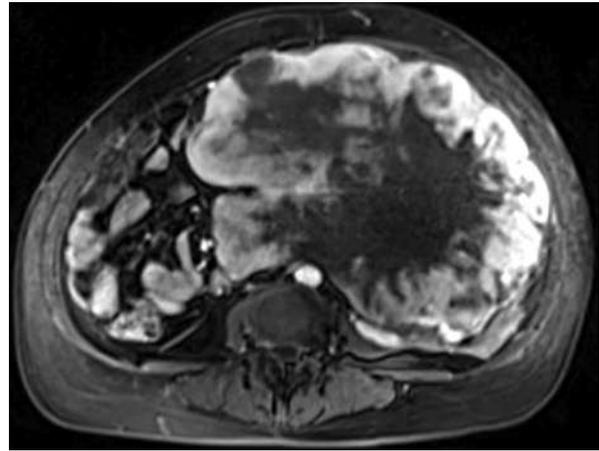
T1-weighted axial tomograms after contrast admission of a large lobulated mass in the left hemiabdomen with central necrosis
